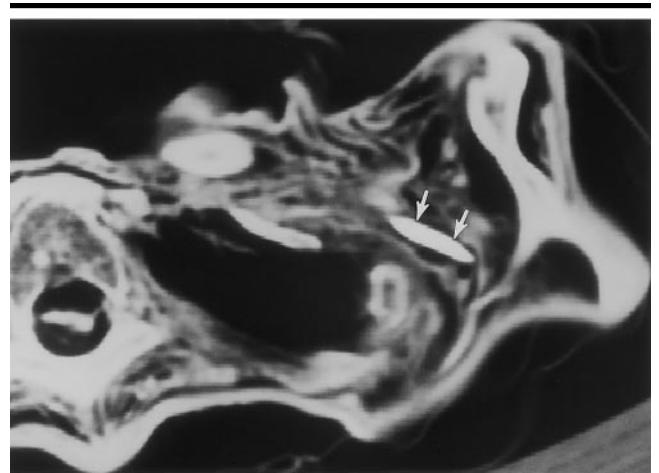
Transverse CT section through the shoulder region (obtained on September 25, 1991) shows a fusiform opacity (arrows), later shown to be an arrowhead lodged between the ribs and the left scapula.
